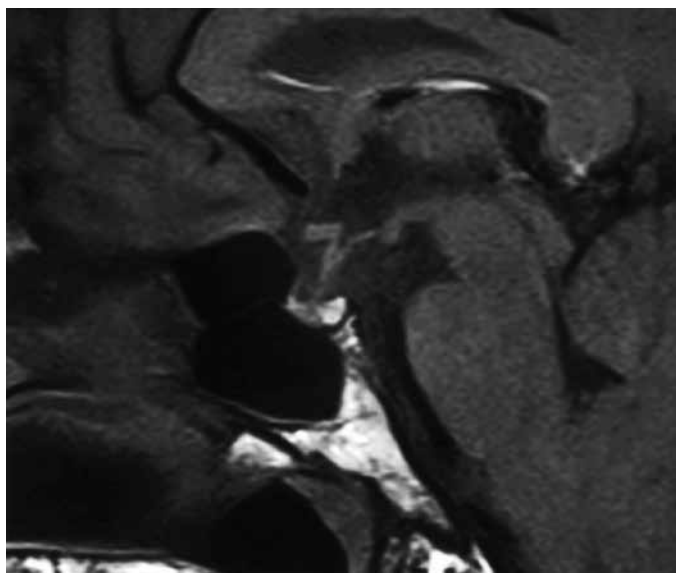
Sagittal section of sellar MRI through median part of pituitary and stalk demonstrating thickening of the stalk
